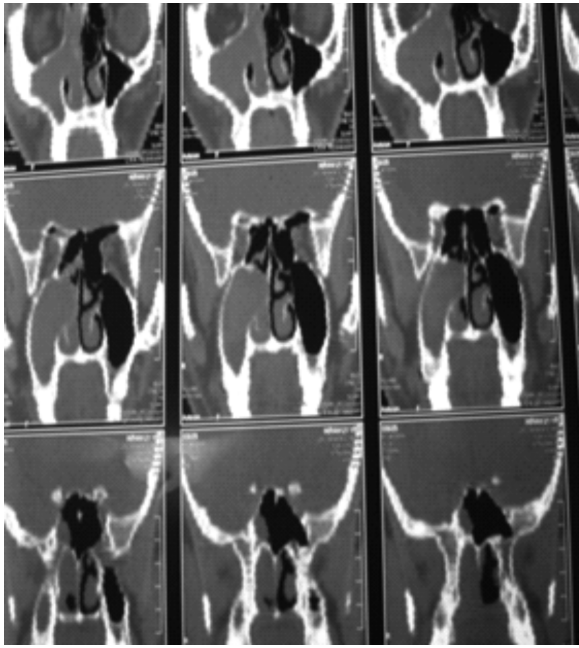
CT scan of nose, nasopharynx, paranasal sinuses and skull base coronal and axial views showing antrochoanal polyp occupying right nasal cavity, right maxillary and nasopharynx.
